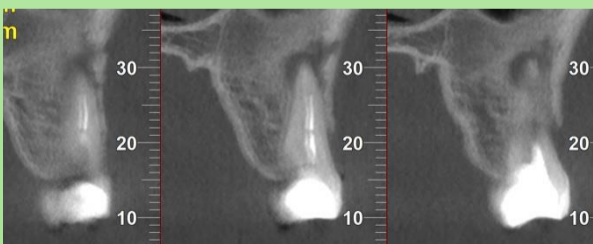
Pre-operative CBCT images
